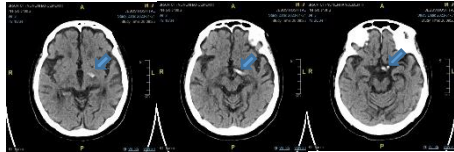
Brain CT(NE): Subarachnoid hemorrhage along the left visual tract.
